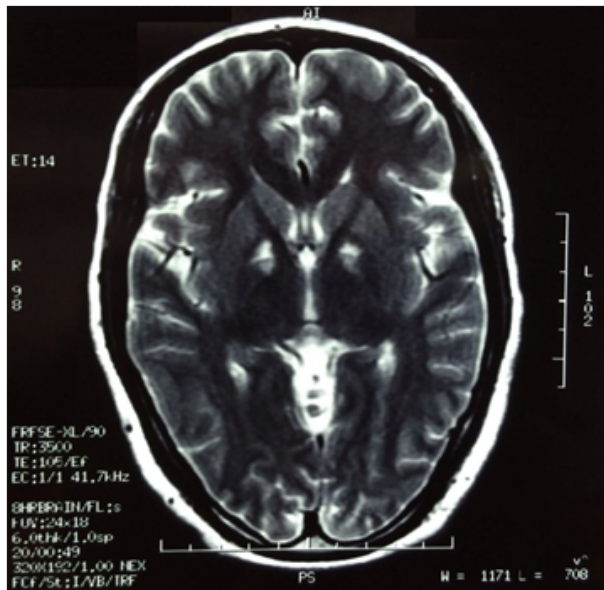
Brain MRI revealed bilateral symmetric abnormal signals in the lenticular nucleus areas
